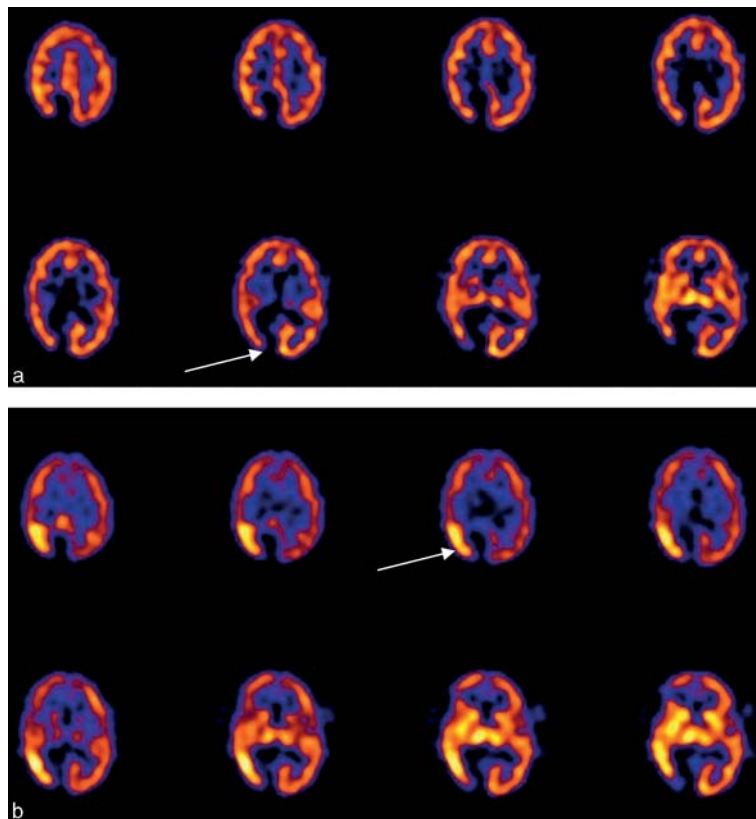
Transaxial SPECT images of ^{99m}Tc bismuth citrate in a patient with seizures: (a) interictal scan; (b) ictal scan. The interictal scan in (a) shows decreased activity in the region of prior surgery with mildly decreased activity in the adjacent cortex (thin arrow). The ictal scan in (b) shows the surgical area as decreased perfusion, but there is an intense focus of activity in the adjacent cortex (thin arrow), clearly delineating the seizure focus.
